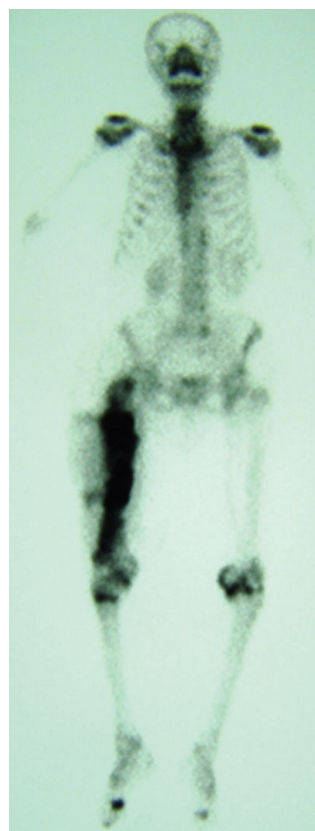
Technetium-99m hexamethyl propylene amine oxime leukocyte labeled bone scintigraphy.
